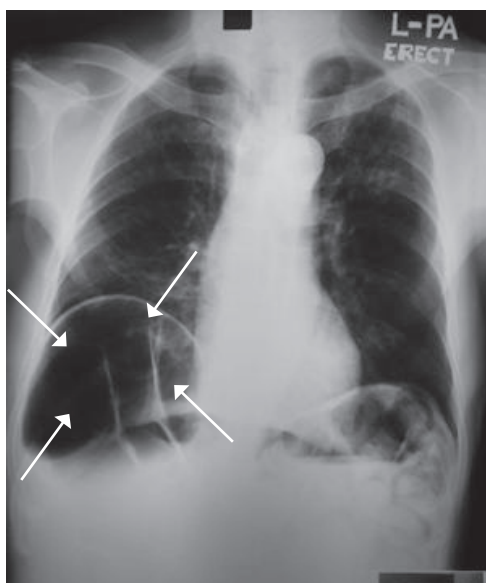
Chest radiograph of TSF showing the right hemidiaphragm (*arrows*) along with a distended colon and with air separating the diaphragm and the liver. Note the haustra of the colon (*arrow heads*)
